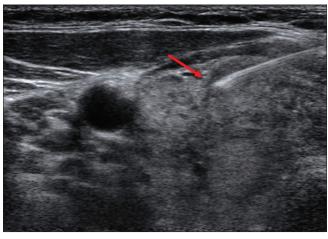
The ultrasound-guided fine-needle aspiration from an isoechoic solid nodule with a rim calcification and a diameter of 4.9 mm (EU-TIRADS 3), which was proved by cytology to be a nodular goiter. EU-TIRADS: European Thyroid Imaging Reporting and Data System. Red arrow shows the nodule
